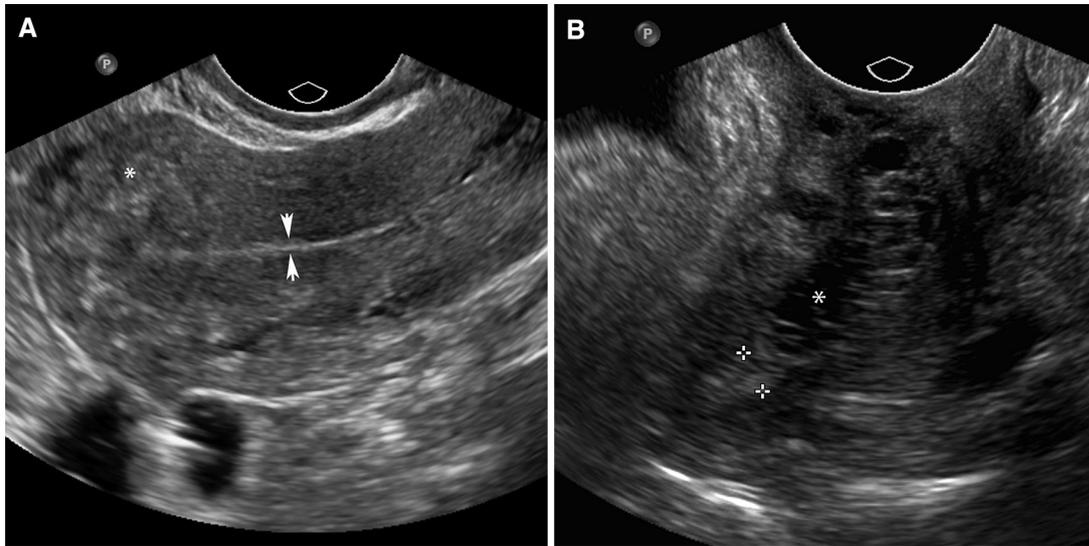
(A) A 51-year-old woman with postmenopausal bleeding. Transvaginal sagittal ultrasound (US) shows atrophic endometrium that measures 2 mm (arrowheads; typically less than 5 mm). The myometrium is heterogeneously echogenic in the fundus due to calcified arcuate arteries (asterisk). (B) A 91-year-old female with postmenopausal bleeding. Transvaginal sagittal US shows multiple cysts in the endometrium in the body and lower uterine segment (asterisk) where the endometrium measures 8 mm. At the fundus, the endometrium measures 4.5 mm (calipers). Because of vaginal bleeding, patient had endometrial biopsy that revealed benign cells. This is an example of endometrial cystic atrophy.
